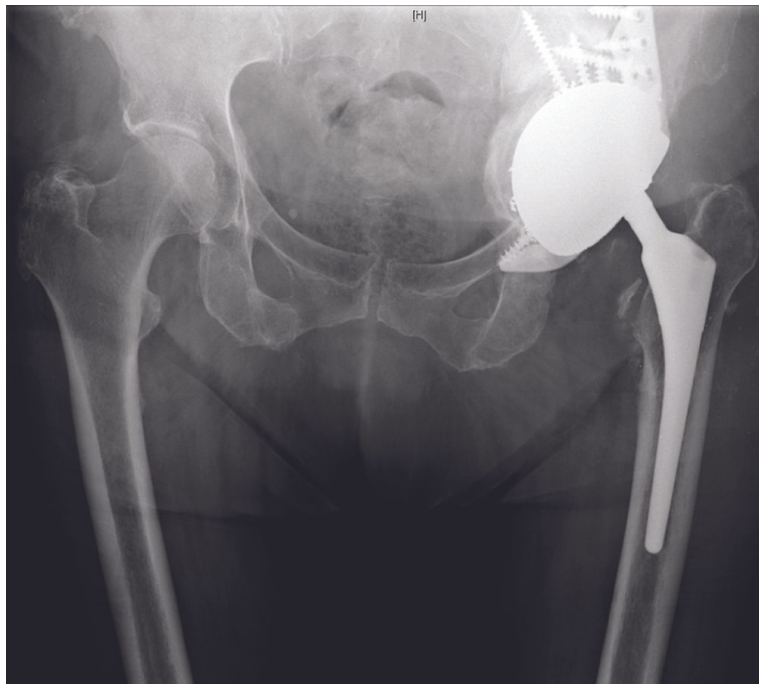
Postoperative radiograph showing a cup-cage reconstruction with a dual-mobility cup.
